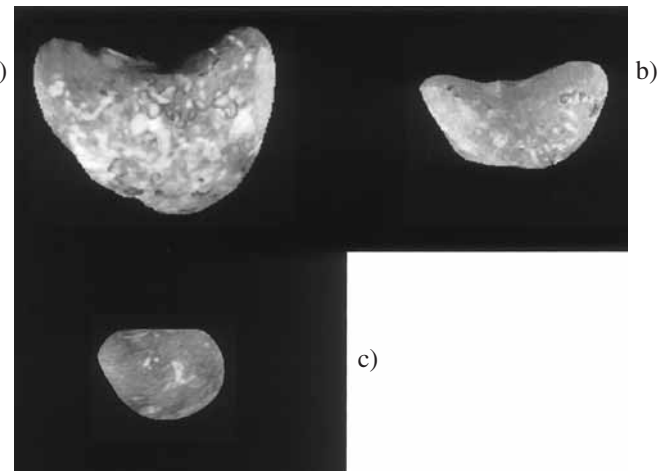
An example of invasive cervical cancer analyzed by 3D color power Doppler ultrasonography: a) before treatment, b) 1 month after treatment, and c) 2 months after treatment.
